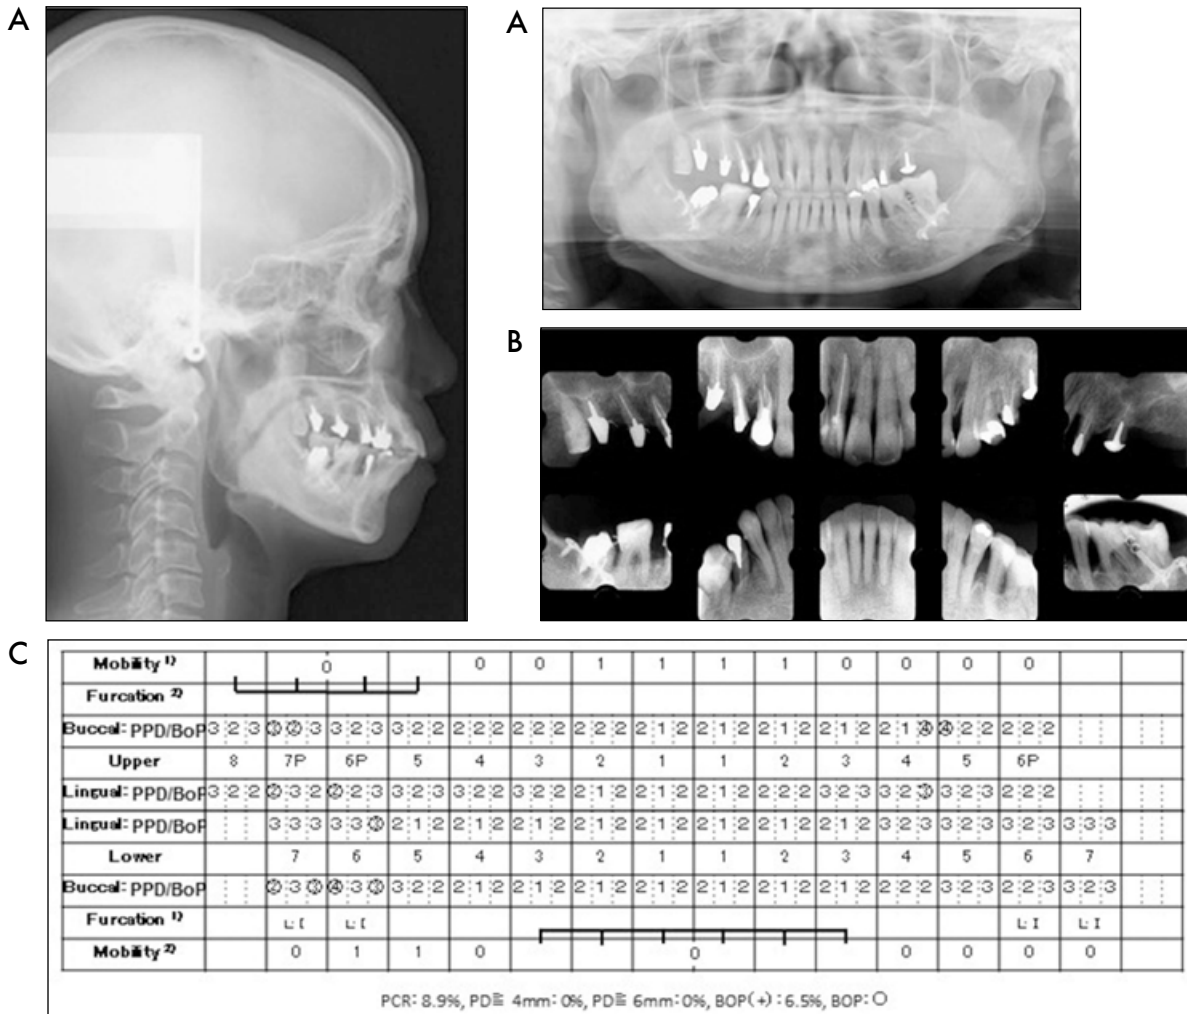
Clinical conditions at the end of the active orthodontic treatments. A: Pantographic and cephalometric X-ray photographs. B: Periapical radiographs. C: Periodontal chart. 1) According to the classification by Miller (1964), 2) According to the classification by Hamp et al. (1975). PPD: Probing Pocket Depth, BoP: Bleeding on Probing.
